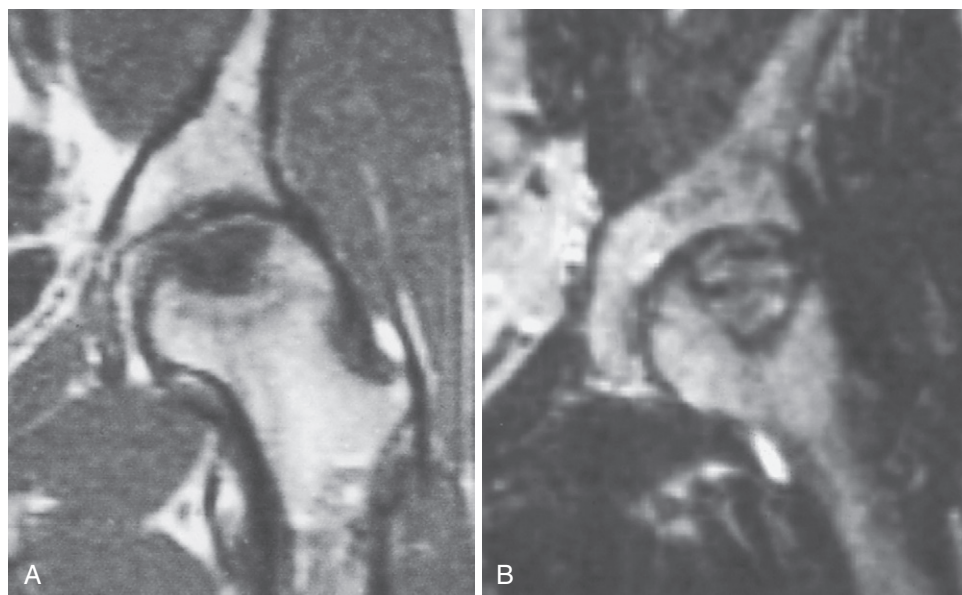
A, On T1-weighted coronal magnetic resonance image of the left hip, the osteonecrotic segment in the subchondral portion of the femoral head shows low signal intensity. B, On T2-weighted coronal image, the necrotic bone exhibits high signal intensity, surrounded by a sclerotic low-signal rim.
